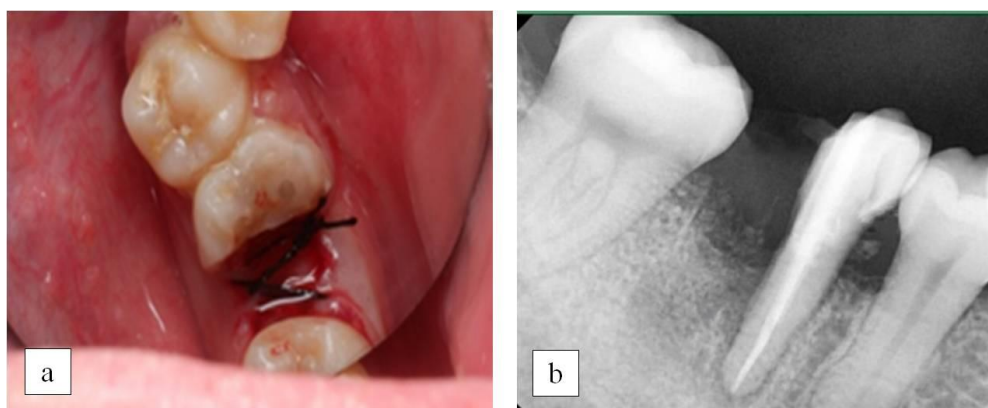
(a) Gingiva sutured with a figure-of-8 technique; (b) Radiograph after tooth separation and distal root extraction on the same day.
